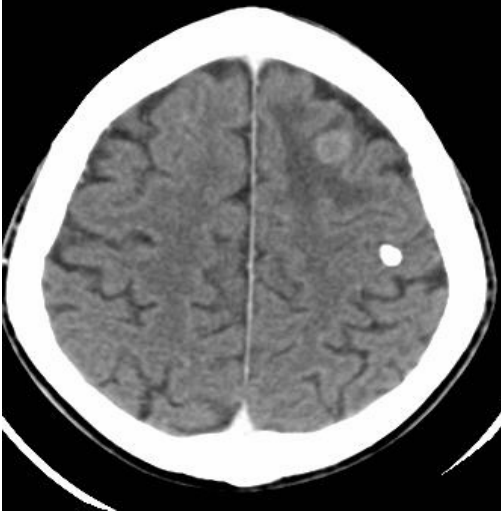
CT SCAN FINDINGS AND UNDERLYING CAUSE
